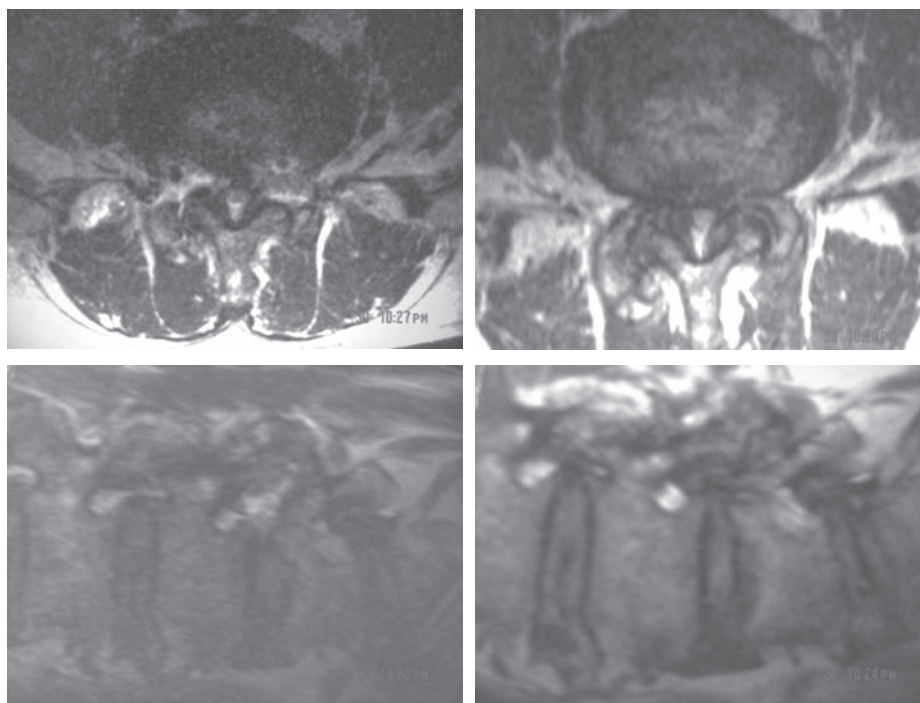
left upper is pre-operative axial MRI, right upper is post-operative axial MRI, Left lower is pre-operative sagittal MRI, right lower is post-operative sagittal MRI after undercutting the facet joint, partial annulectomy, resect the ligament and osteophytes, the foraminal area is decompressed.
